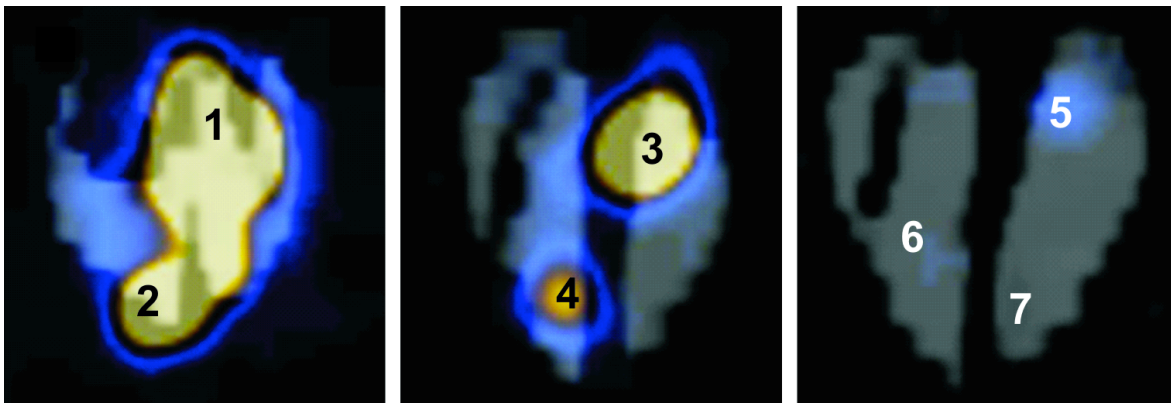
Ex vivo SPECT-CT Imaging einer Verdünnungsreihe NIS⁺-hiPSCs nach intramyokardialer Applikation
